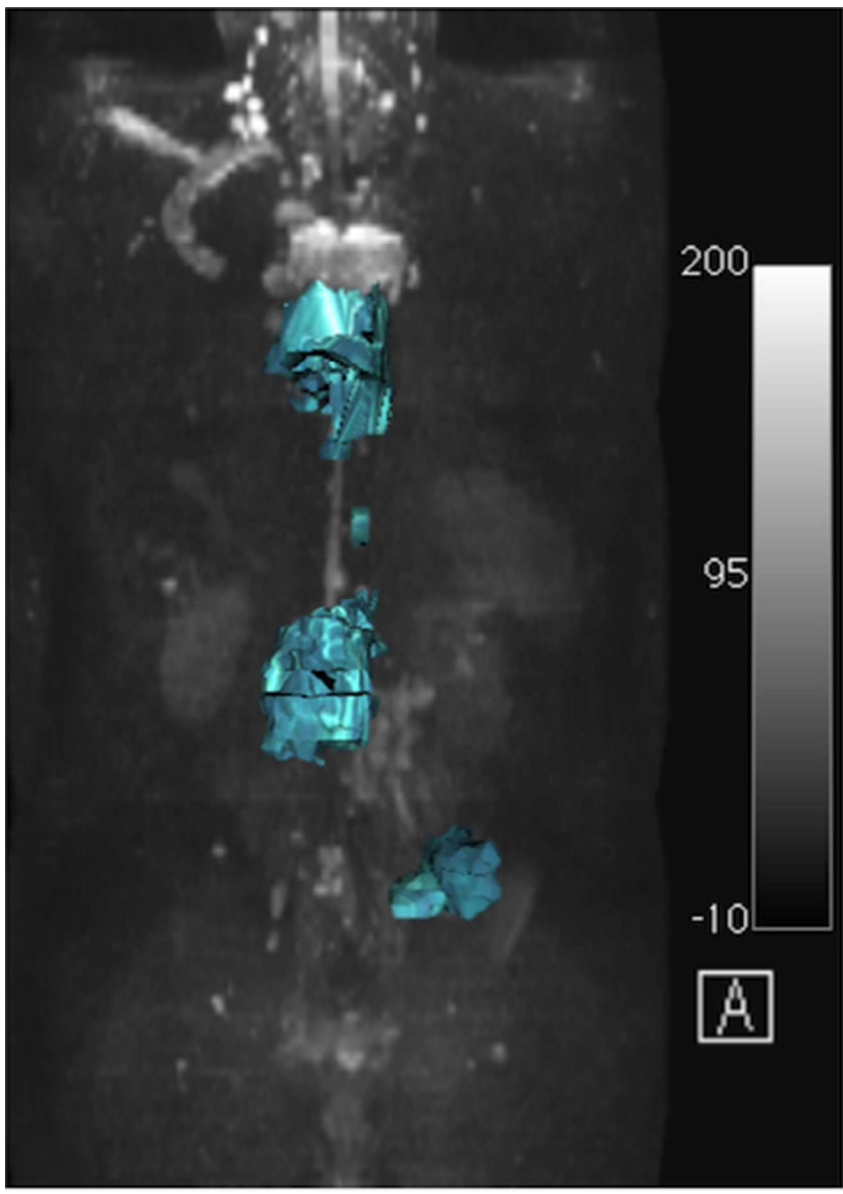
Images of mCRPC in a 70-year-old man responding to olaparib showing reduction in the b900 DWI signal abnormality extent on maximum intensity projection images ($b=900 \text{ s/mm}^2$) at baseline (a) and after 12 weeks of treatment (b). The histogram (c) depicts the ADC values of the tDV at baseline and after 12 weeks on treatment, showing an increase in the mADC.
